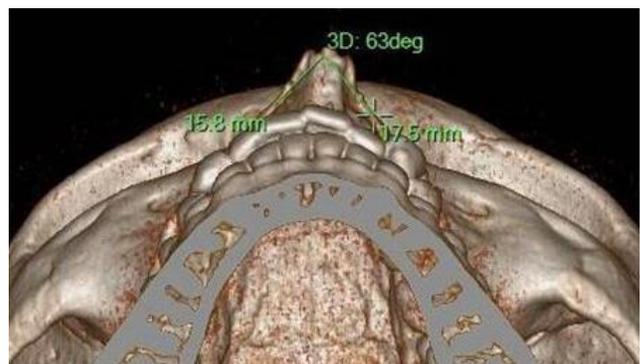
3D CT image showing the measurement of Pyramidal Angle
